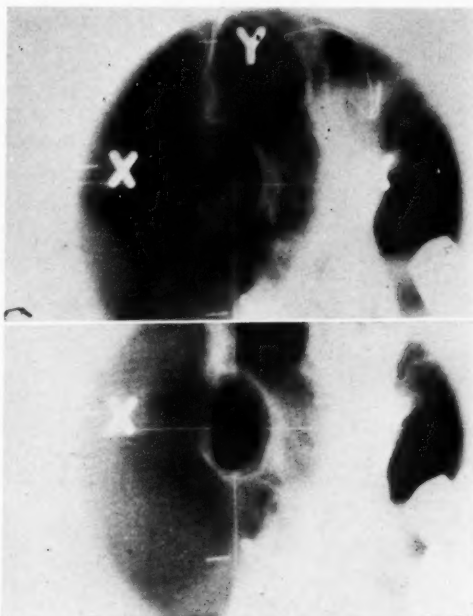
Upper portion: Lateral roentgenogram of the sella turcica in correct alignment for proton irradiation. Lower portion: Same, except that the proton beam was turned on momentarily to make an autoradiograph.
